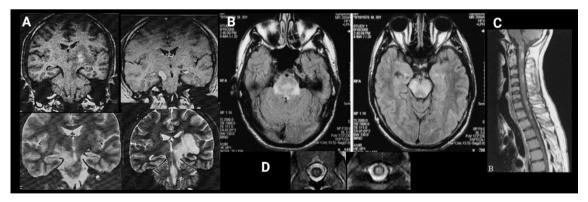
MRI in NeuroBehçet: A. brainstem lesions with variable extension, down are visible voluminous lesions, with mass effect and basal nuclei involvement B. bilateral extensive involvement of pons and midbrain C. Several short extended cervicodorsal spinal lesions D. Spinal cord Bagel sign (Siva, 2018)
